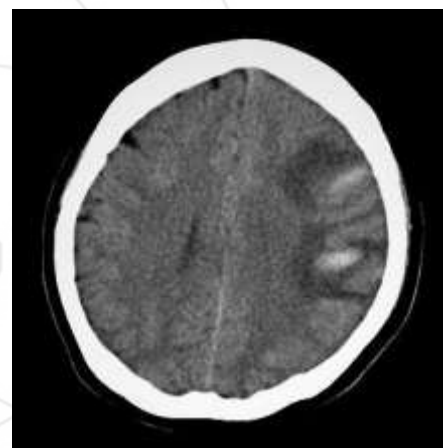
CT showing hemorrhagic transformation of acute infarct
